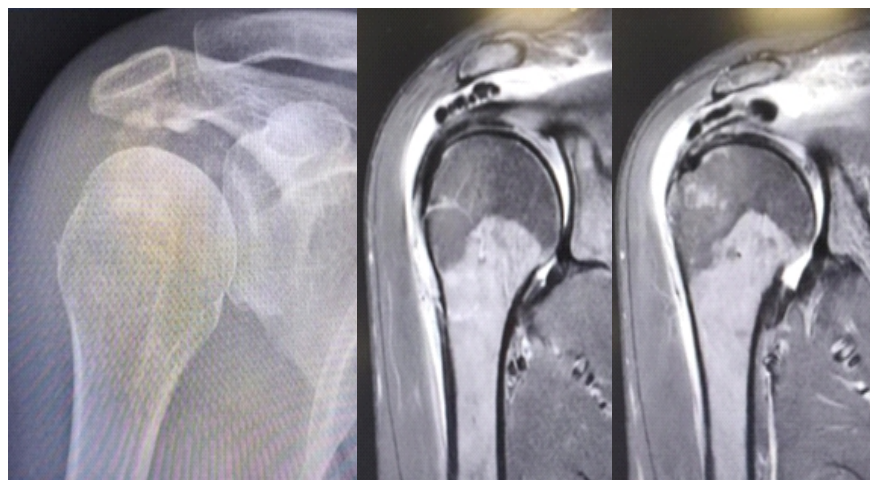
Imaging evaluation with X-rays and magnetic resonance imaging demonstrating calcific deposits within the subacromial space.
